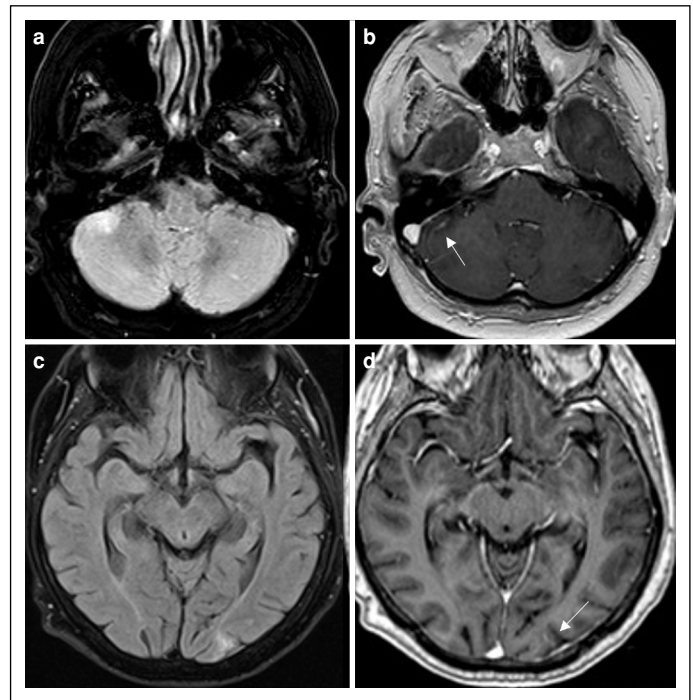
Follow-up brain MRI of the patient. FLAIR images (a and c) and post-contrast T1W images (b and d) show regression of both focal signal intensities and patchy enhancements (arrows).
